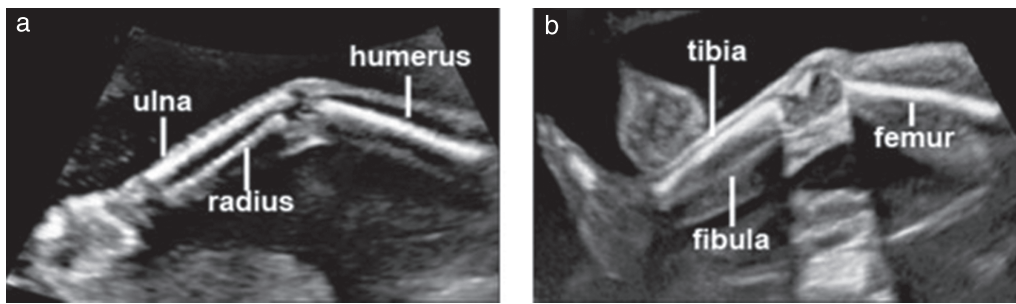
Sonography of the fetal upper (a) and lower (b) extremities. The presence or absence of the upper and lower limbs should be documented routinely unless they are poorly visualized due to technical factors.
